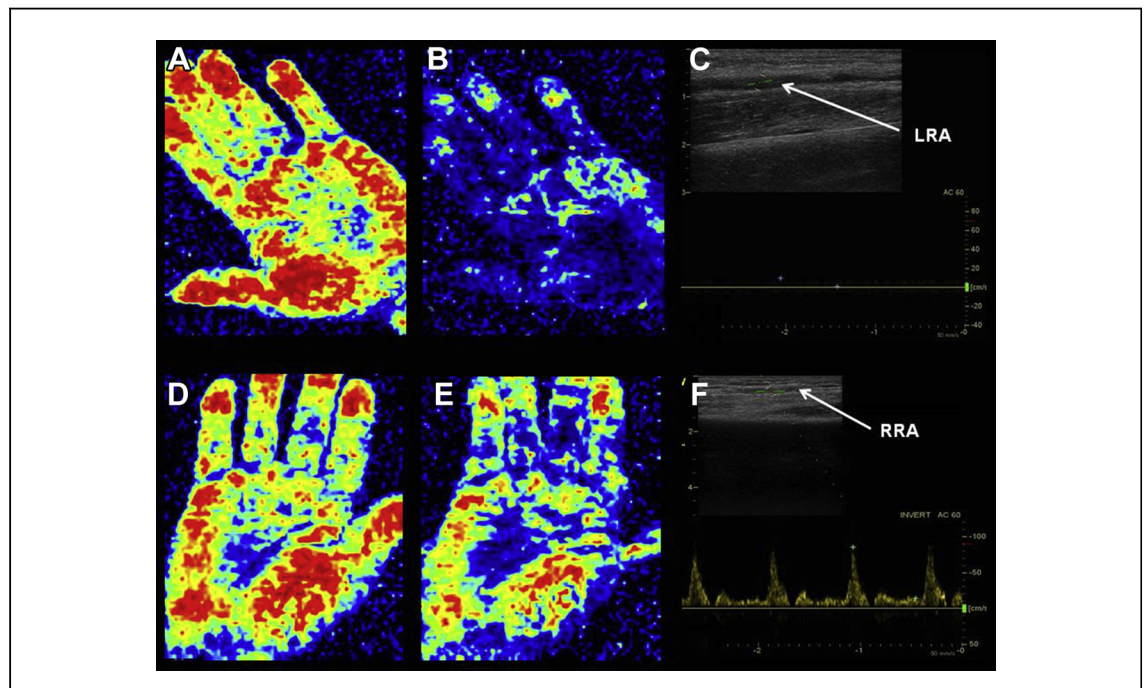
Laser Doppler and Echo Doppler Evaluation of a Radial Artery Occlusion
